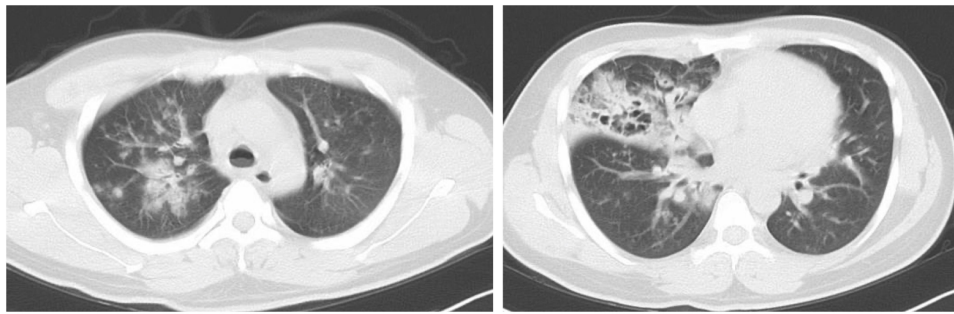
A chest computed tomography (CT) scan in Case 1 shows infiltrative and nodular shadows with pneumatocele formation in the right upper lobe.
